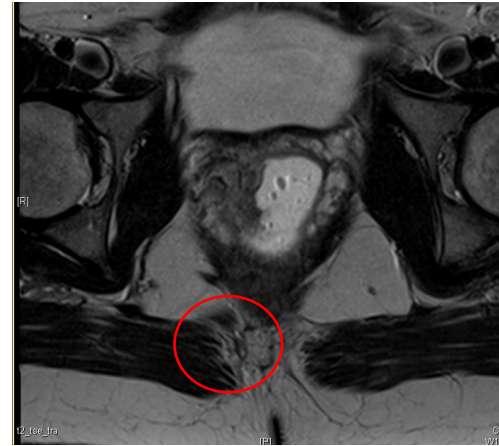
MRI finding of lesion
